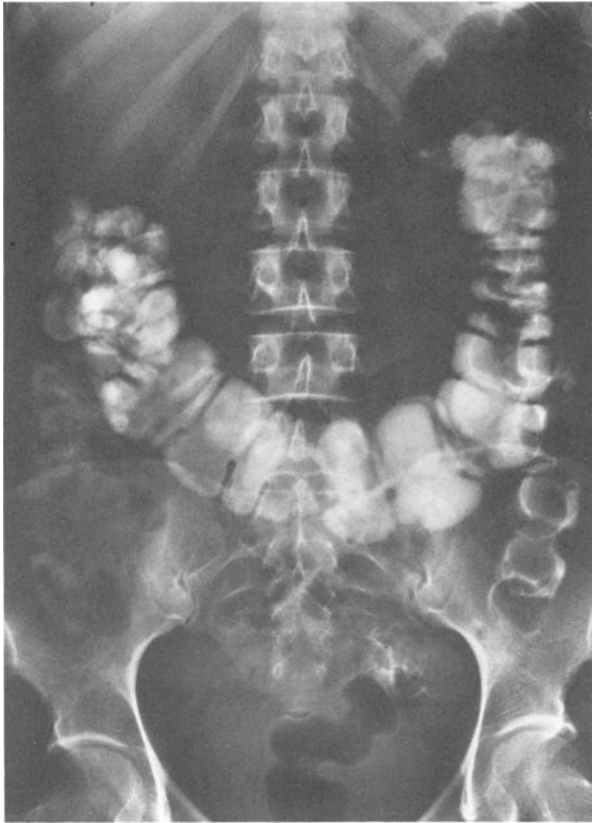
Same patient: roentgenogram performed 40 h after the administration of the contrast compound. Twenty-three packages remained to be eliminated.
